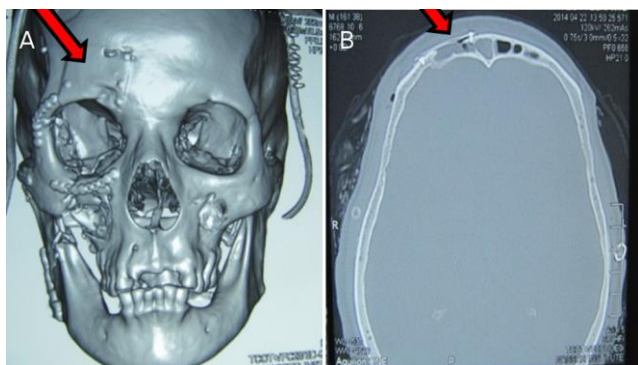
a) 3D CT showing titanium mesh reconstruction of the anterior table of frontal sinus and reduction and fixation of the right ZMC with plates and screws; b) Immediate Postoperative Axial CT, showing a reduced anterior table of the frontal sinus and fat in the sinus cavity
